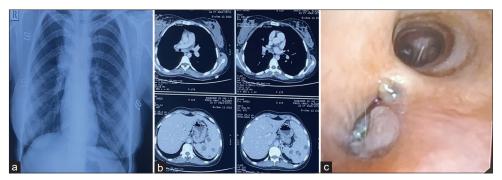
(a) Chest X-ray suggestive of right paratracheal and mediastinal opacity, (b) CECT thorax and abdomen shows multiple enlarged mediastinal and right hilar lymph nodes with granulomatous lesions in the splenic parenchyma, (c) bronchoscopic image showing growth in the right main bronchus
